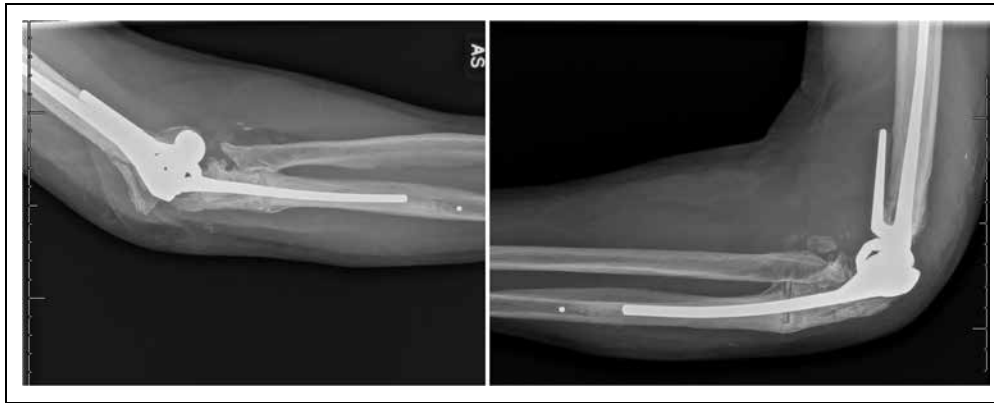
Radiographs of the elbow 8 months postoperatively showing healed ulnar osteotomy and heterotopic ossification formation.
